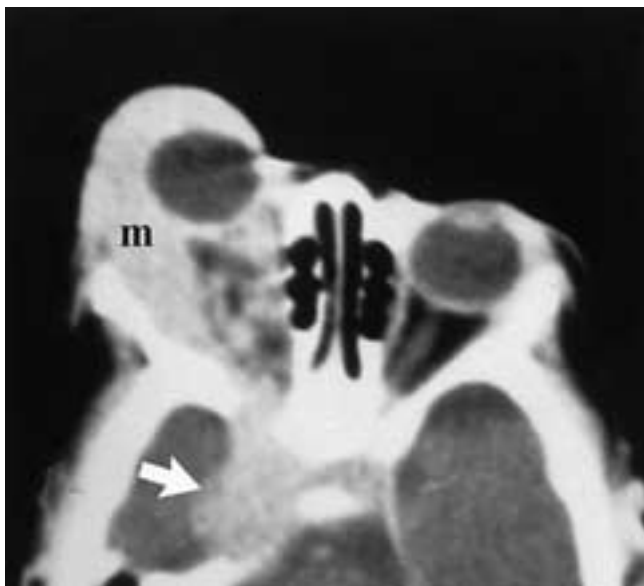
Capillary hemangioma. Postcontrast axial CT scan shows an enhancing mass (m) with involvement of the eyelid and extension into the right cavernous sinus (arrow).
